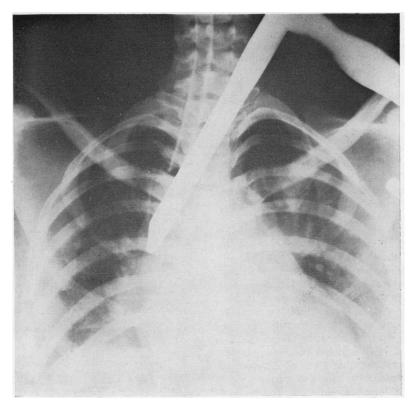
Radiograph showing laryngoscope in position.
